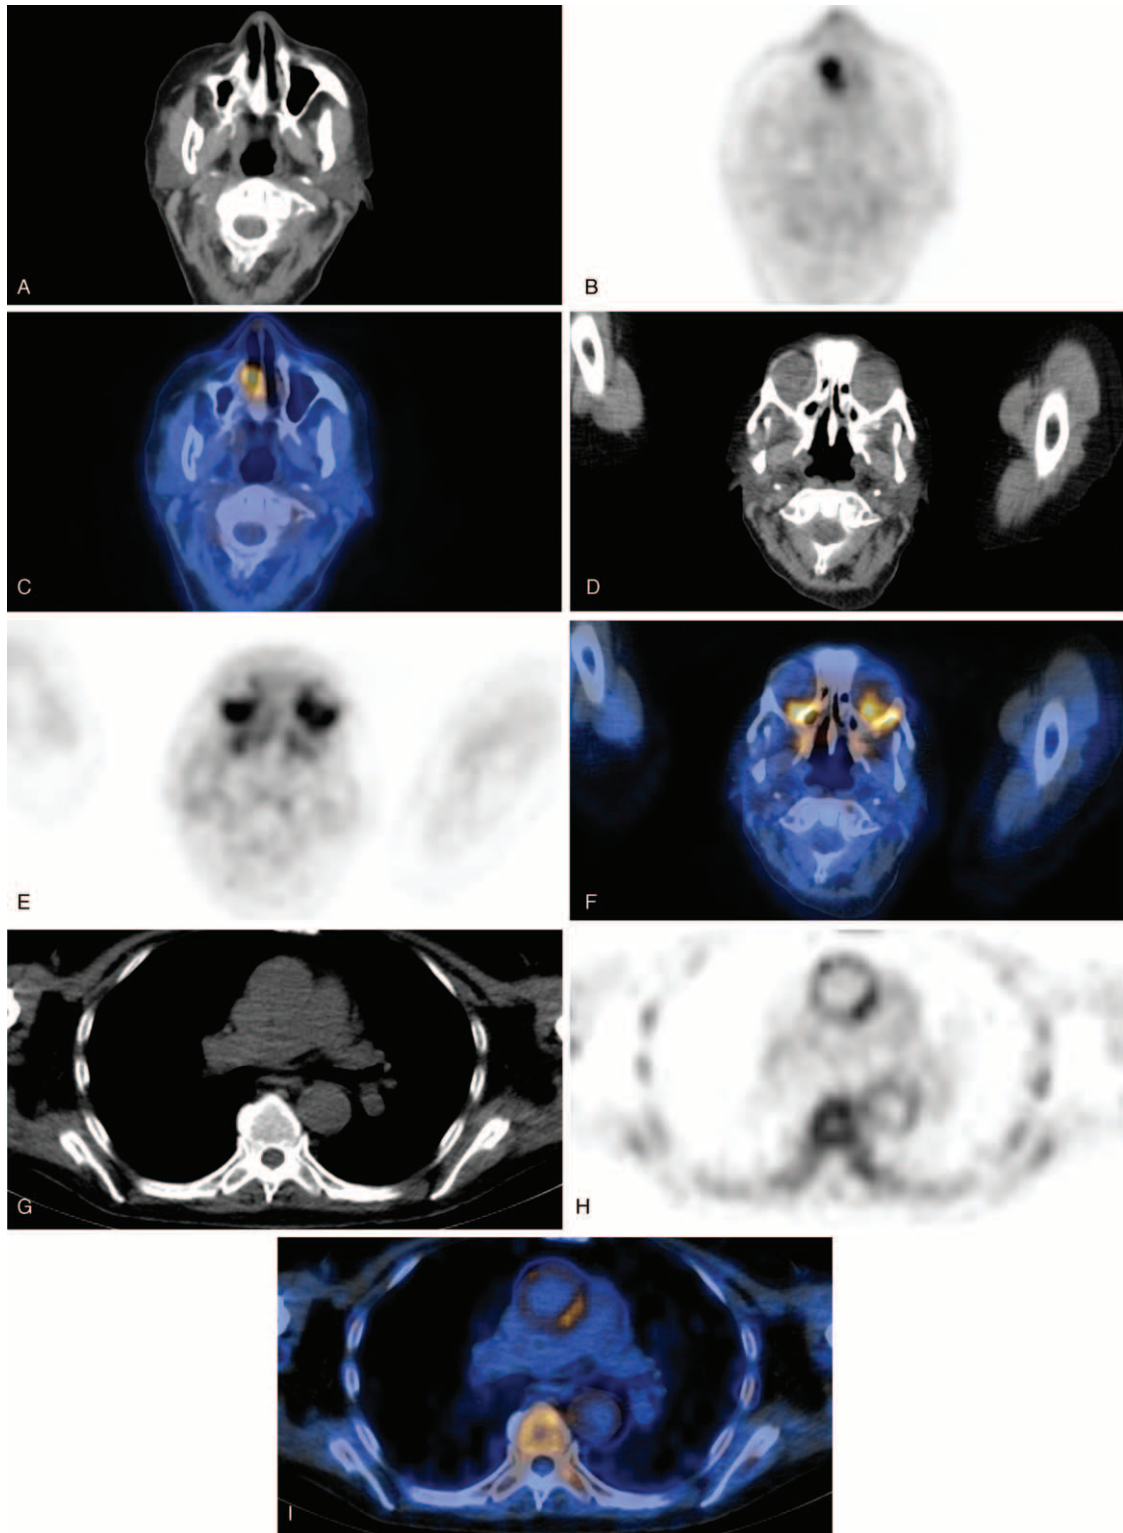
Examples of fusion PET/CT images of AAV patients during a period of suspected active disease. (A) CT scan, (B) PET scan, and (C) fusion PET/CT of a patient with suspected nasal involvement. (D) CT scan, (e) PET scan, and (F) fusion PET/CT of a patient with suspected ocular involvement. (G) CT scan, (H) PET scan, and (I) fusion PET/CT of a patient with enhanced uptake in the aorta and bone/bone marrow (occult lesions). (J) CT scan, (K) PET scan, and (L) fusion PET/CT of a patient with aortitis and cervical pachymeningitis (occult lesions). AAV = anti-neutrophil cytoplasmic antibodies-associated vasculitis, CT = computed tomography, PET = positron emission tomography.
